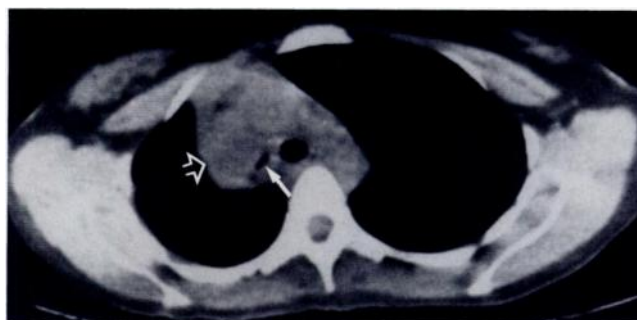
CT image immediately inferior to carina. Adenoid cystic carcinoma narrows and distorts right upper lobe bronchus (*arrow*). Right upper lobe is collapsed (*open arrow*).
